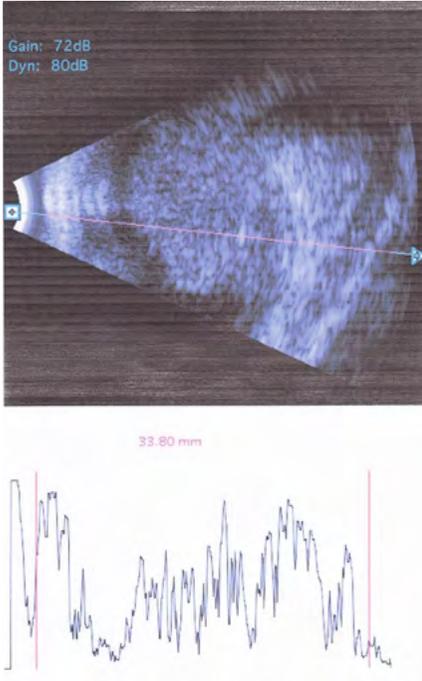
Ocular ultrasound shows a hyper-echoic homogenous mass in the retina with moderate to high reflectivity in A scan.
